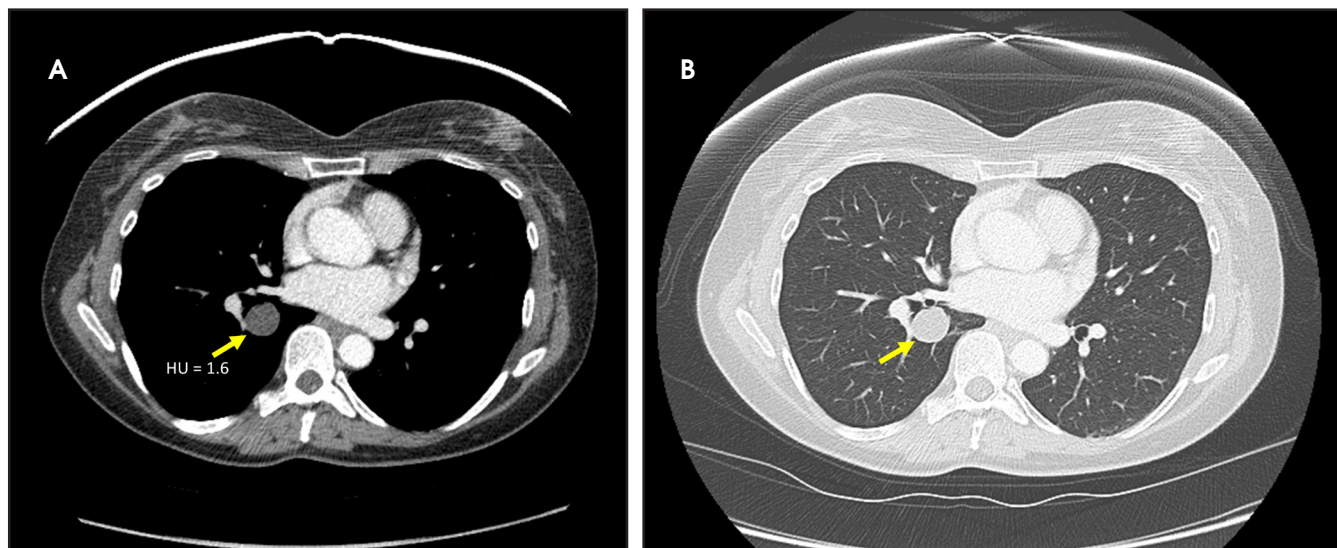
Axial images from a contrast-enhanced chest CT are presented in both soft tissue (Figure 2A) and lung (Figure 2B) windows. There is a nonenhancing, round mass in the right lower lobe (arrow). Hounsfield units (HU) measure 1.6, indicating that this mass is a cyst.
